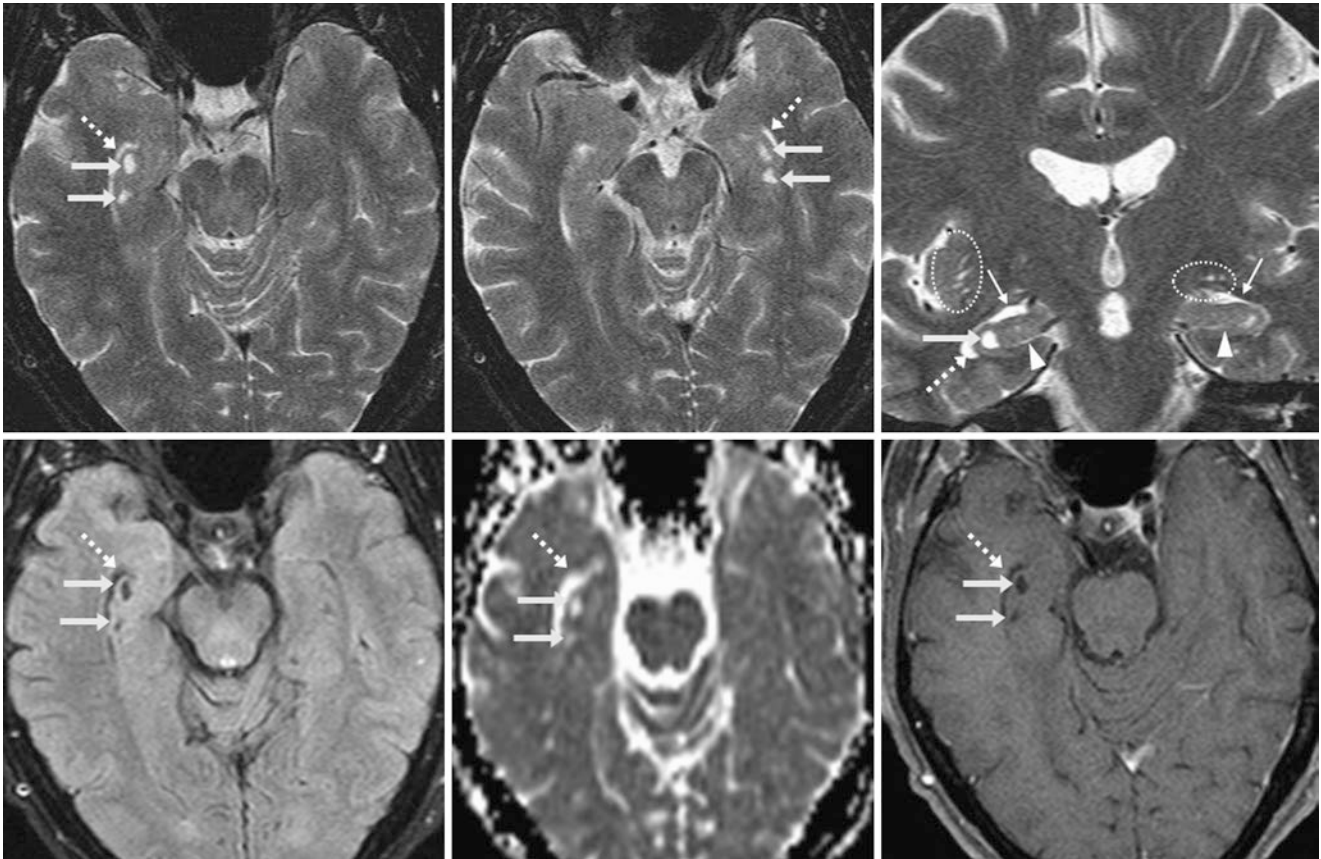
A 62 year old had a 1.5 T MRI. On axial (*top left and middle*) and coronal (*top right*) T2WIs, there are hippocampal cysts bilaterally (*arrows*) medial to the lateral ventricles' temporal horns (*dashed arrows*). On the coronal image, note the asymmetry of the choroidal fissures (*thin arrows*), with mildly enlarged hippocampal fissures
